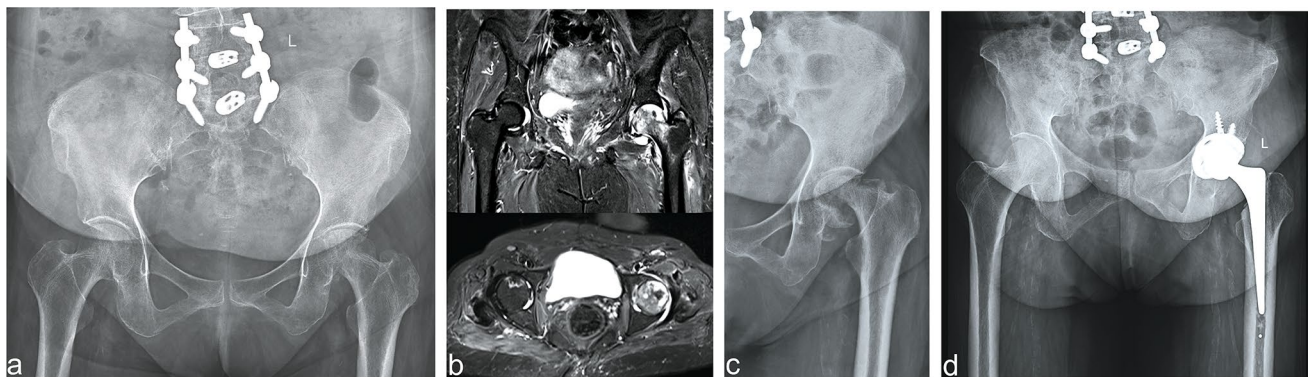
a Radiograph showing subchondral cyst and osteolysis in the left femoral head. b MRI showing severe marrow and periarticular soft-tissue edema with joint effusion. c rapid progression and varus
